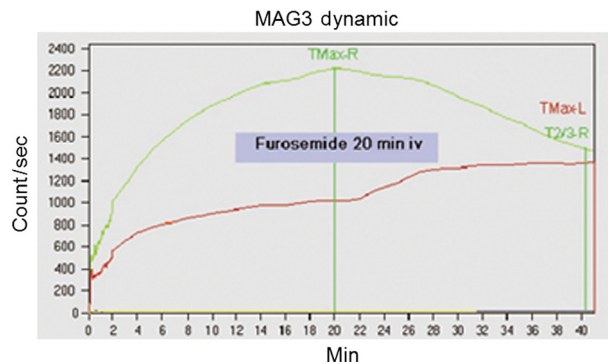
MAG-3 dynamic scintigraphy showed obstructive pattern in bilateral ureters.
